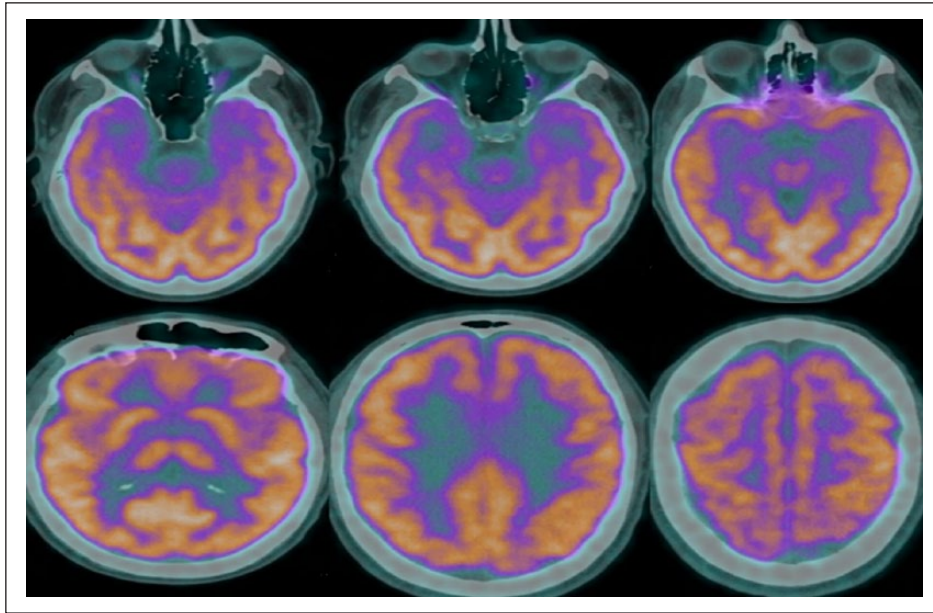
FDG-PET scan revealed temporal hypometabolism and patchy frontal hypometabolism suggestive of FTD.
